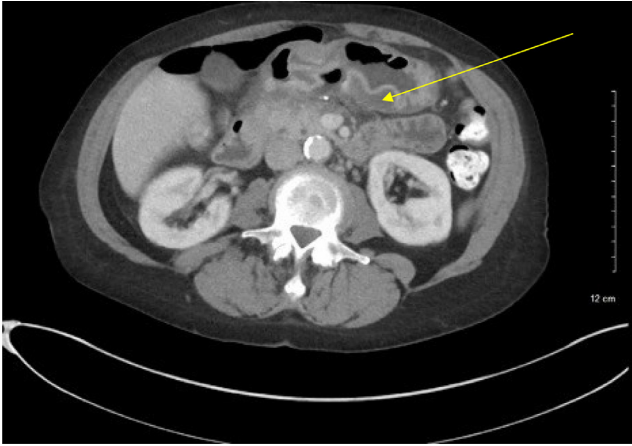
Axial CT abdomen showing peri gastric edema with wall thickening, particularly in the antral and distal fundal region (yellow arrow). It also reveals pneumoperitoneum at the top of the image, which indicates perforation of hollow viscera.
